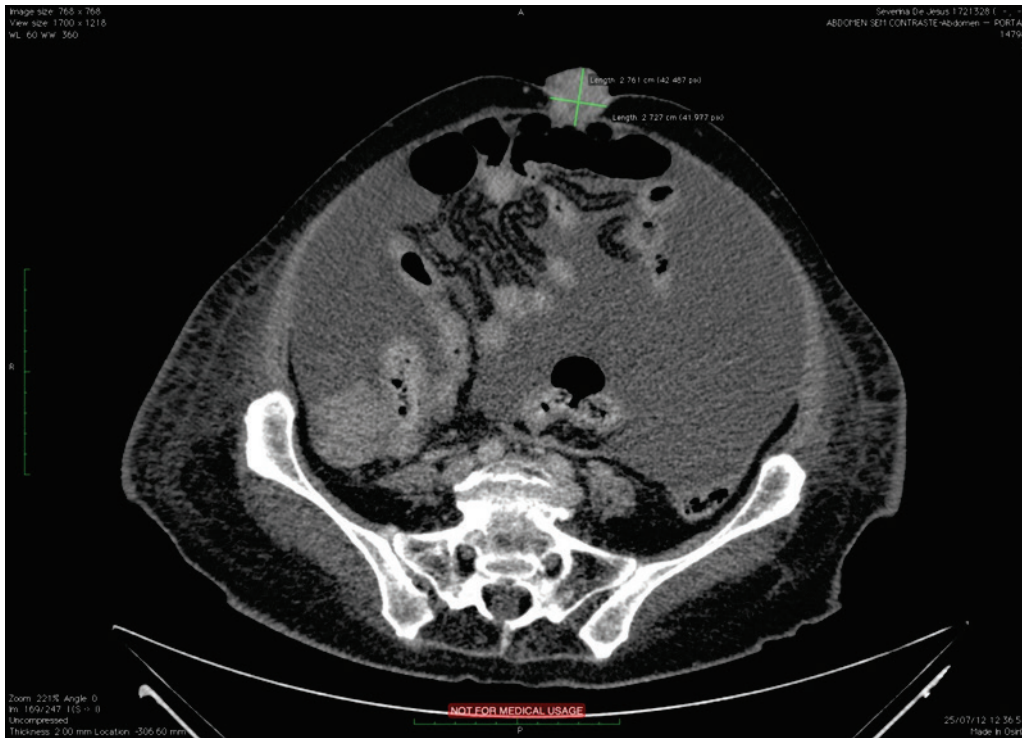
Computed tomography showing umbilical nodule
